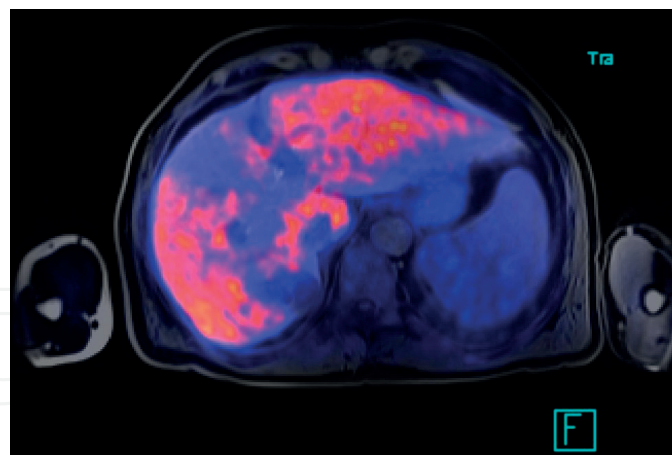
Metastases of colorectal carcinoma in the liver (PET MRI).
